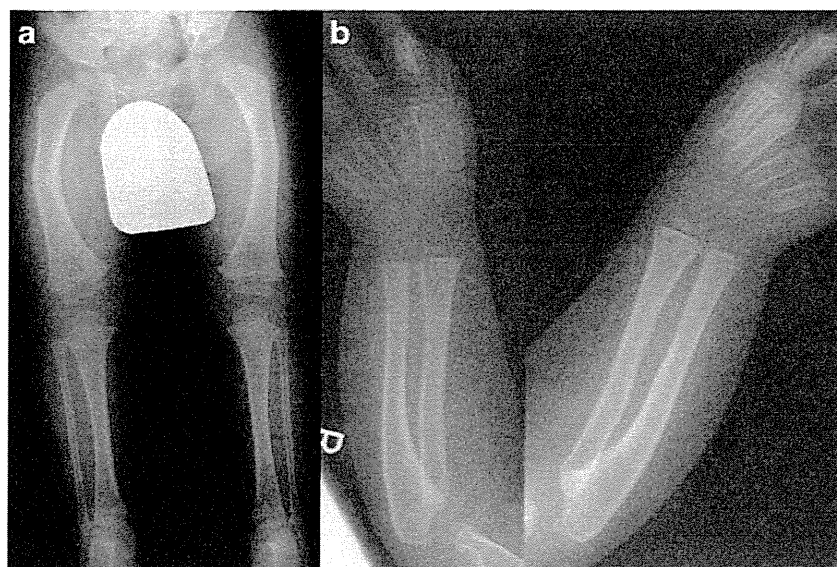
Anteroposterior radiographs in a 2.5-year-old boy with prenatal hypophosphatasia. a Partial improvement of the femoral bowing with cortical thickness at the concave side. b Complete healing of the forearm bowing
